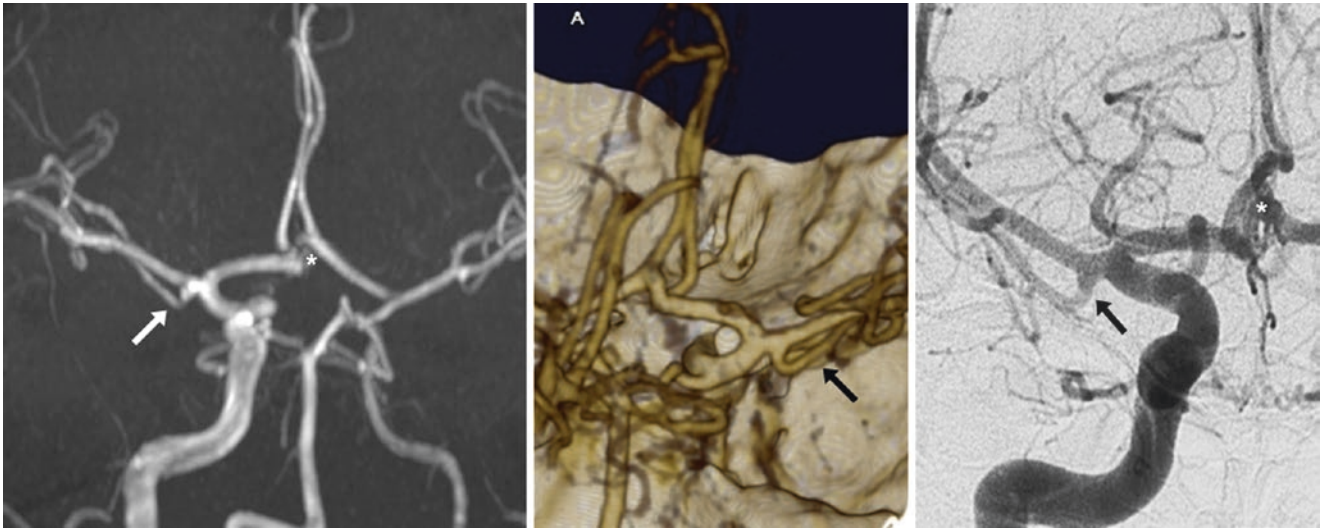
42-year-old with an early bifurcation of the right MCA, likely representing an early anterior temporal branch (arrows), on AP view from a 3DTOF MIP MRA (left), PA view from a 3D VR CTA
